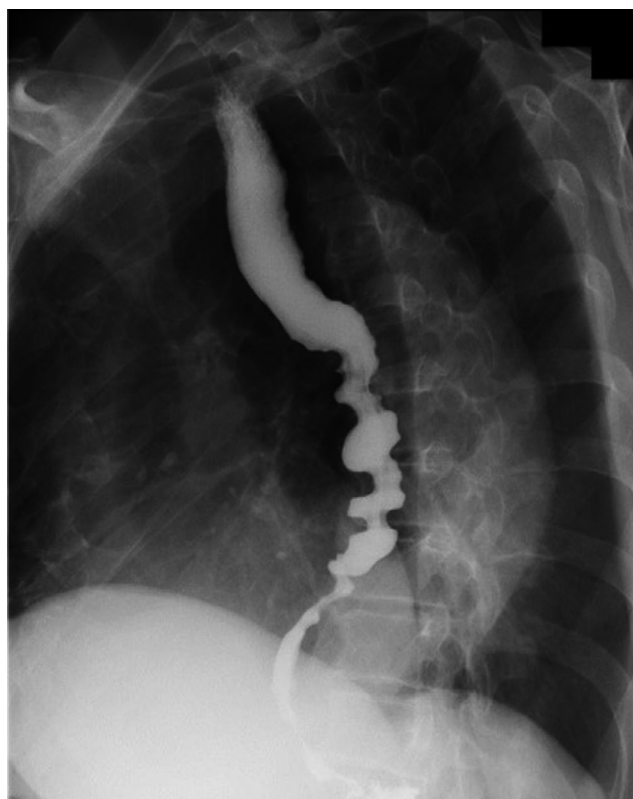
The figure of esophageal radiography
